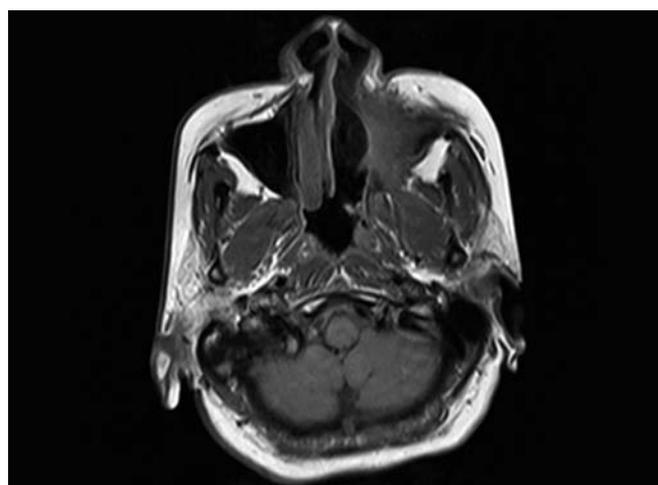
MRI orbits with PNS repeated 3 weeks after second stage of debridement showing substantial clearing of soft tissue lesion seen on previous scan (T1-weighted image, sagittal section)
